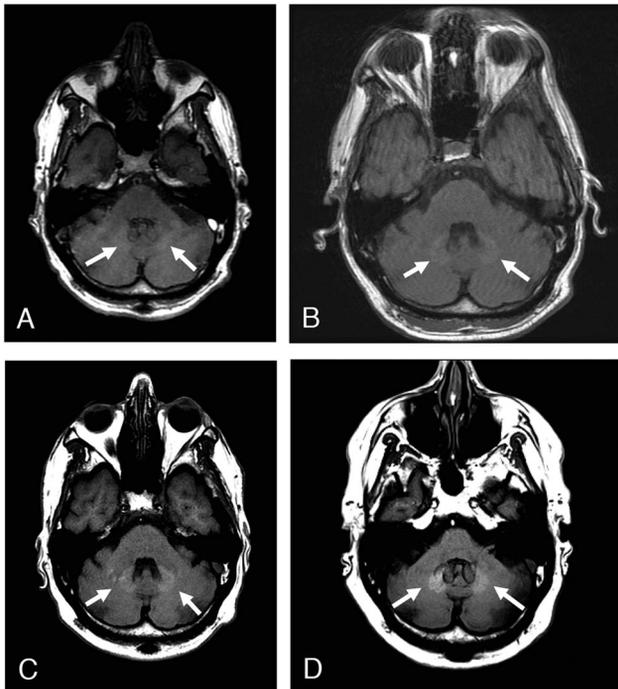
Sequential axial T1-weighted noncontrast magnetic resonance images through the posterior fossa of a 52-year-old male with history of multiple sclerosis demonstrate a progressive increase in signal within the dentate nuclei following repeated doses of gadolinium-based contrast agents in (A) December 2011, (B) June 2013, (C) September 2016, and (D) June 2018.
